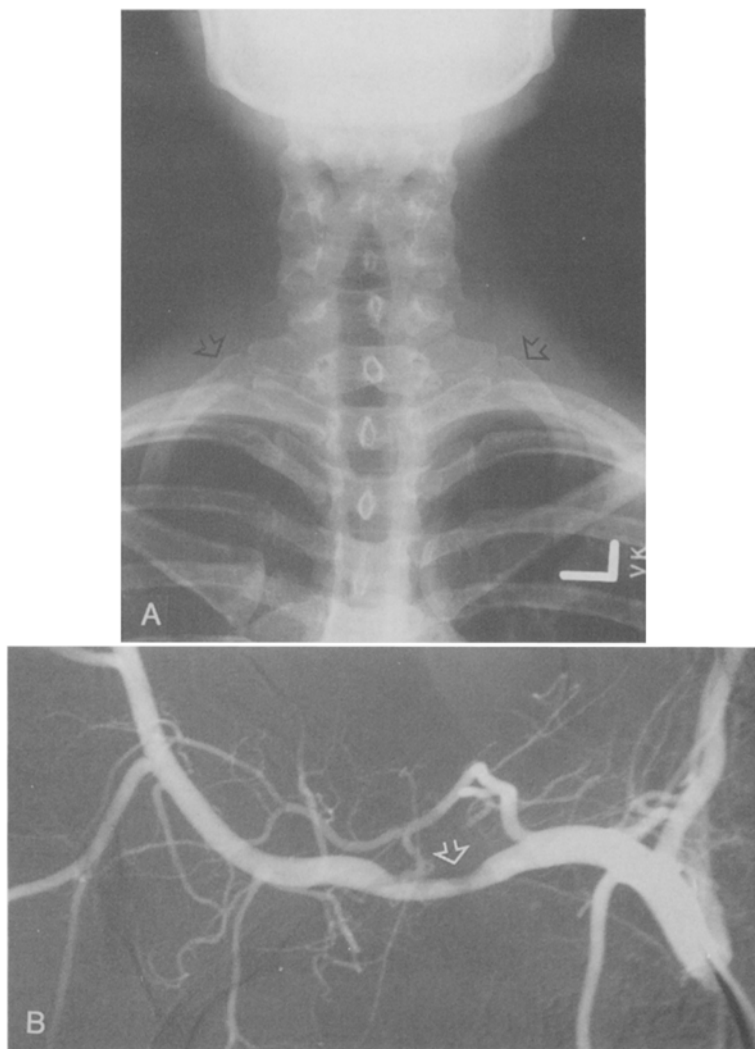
A, PA radiograph demonstrates bilateral anomalous first ribs (*arrow*). B, Angiogram of site of impingement (*arrow*) on superior aspect of right subclavian artery by anomalous, incomplete first rib with abnormal attachment to underlying second rib during hyperabduction maneuver. Note mild poststenotic dilation.
